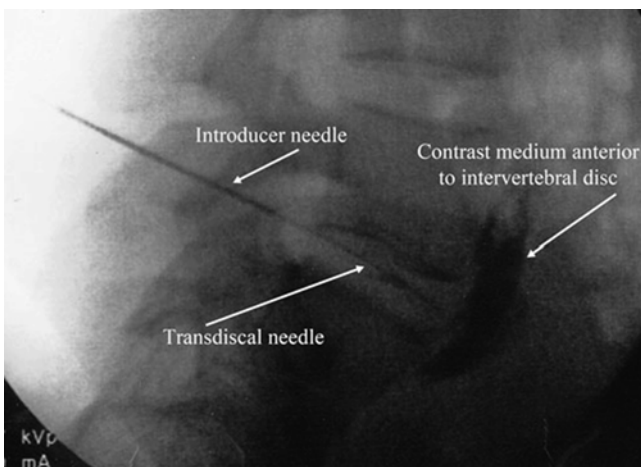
Lateral radiographic view of transdiscal needle
